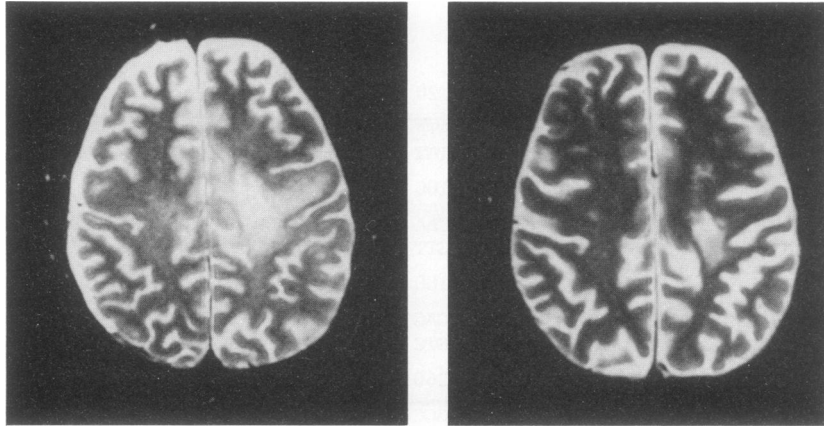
(Left) T2-weighted MRI of the brain of an HIV-1-infected patient with PML showing bilateral white-matter lesion that are quite extensive on the left side. (Right) Repeat T2-weighted MRI obtained following 7 months of 9×10^6 to 12×10^6 U of alpha interferon given subcutaneously daily, showing clear resolution of the white-matter lesions. (Figure provided courtesy of Justin McArthur, Johns Hopkins Hospitals and School of Medicine.)
